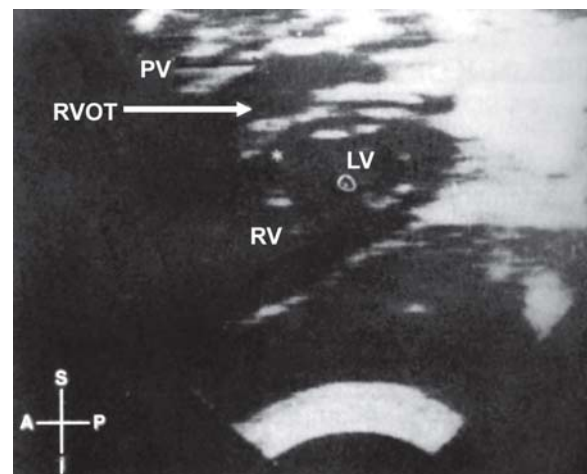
Echocardiography (two-dimensional) in tetralogy of Fallot (TOF)
